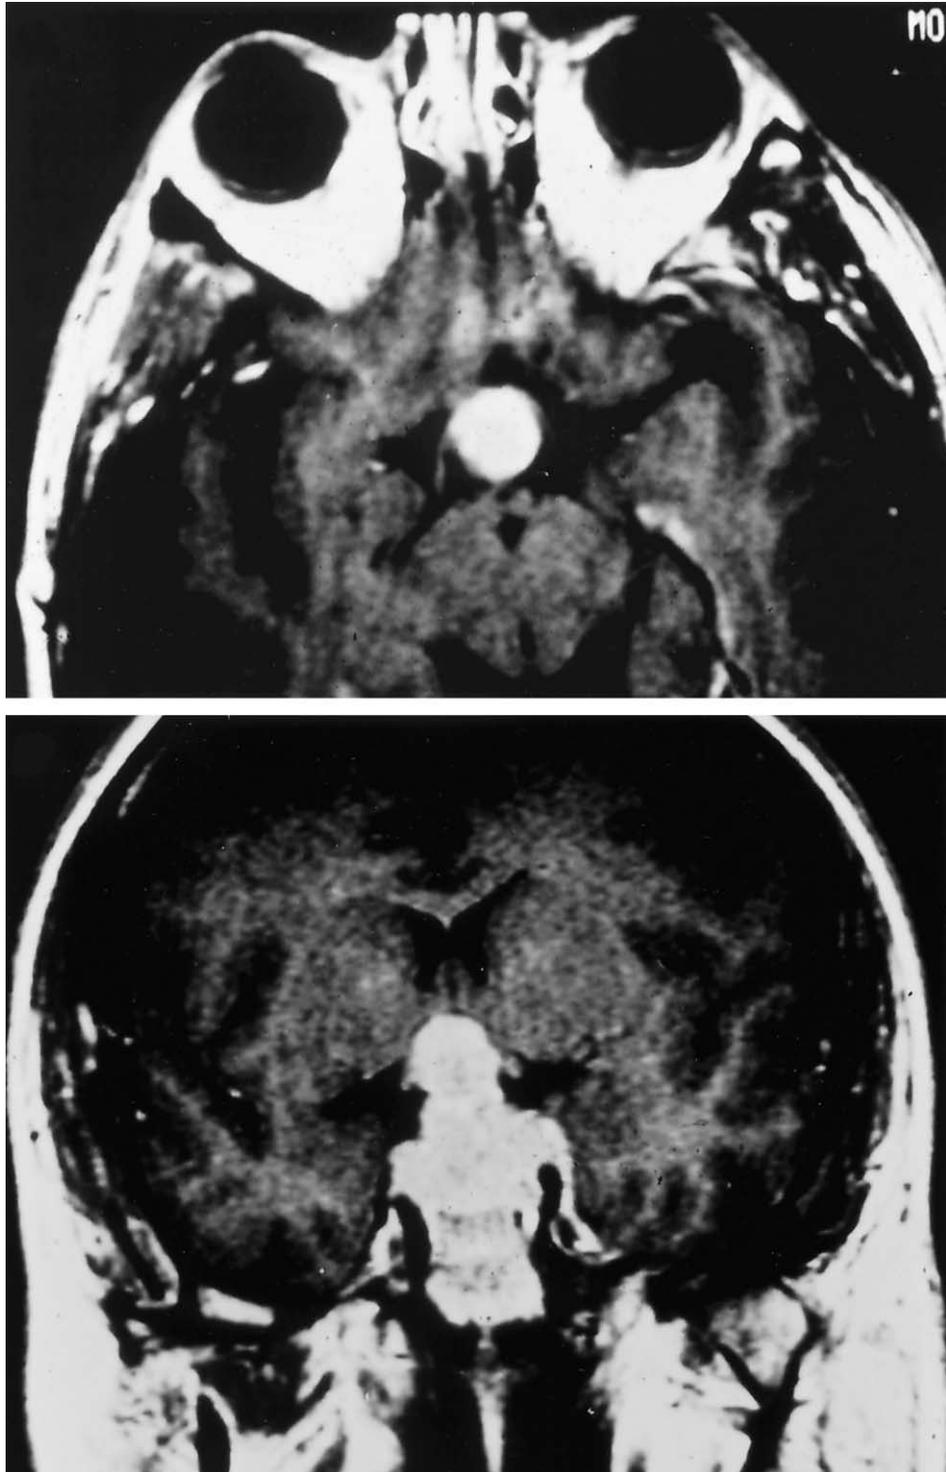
Gadolinium-enhanced T1-weighted axial and coronal magnetic resonance images show generalized enhancement of a large mass involving the sellar and suprasellar regions.
